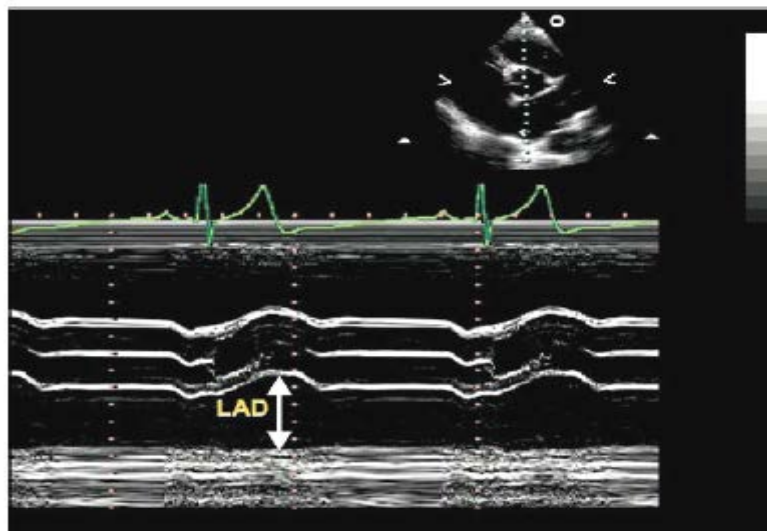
Measurement of left atrial diameter (LAD) from M-mode, guided by parasternal short-axis image at level of aortic valve.
